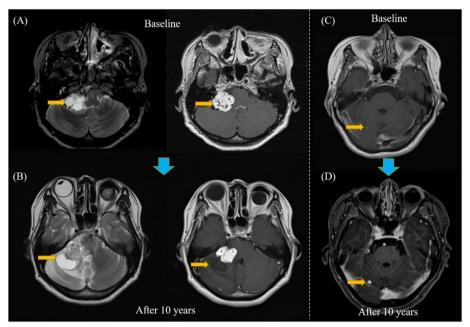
Baseline and 10-year follow-up MRI images of the brains of two male patients in their late 40 s with missense mutations and brain hemangioblastomas with different volumes at baseline. A Axial T2-weighted and enhanced T1-weighted images reveal a relatively large hemangioblastoma (2.5 cm) in the right cerebellum of one patient. B The 10-year-follow-up MRI images show a marked increase in size (4.0 cm), with significant increase in the cystic portion. C Axial enhanced T1-weighted image reveals a tiny hemangioblastoma (0.2 cm) in the right cerebellum of another patient. D The 10-year-follow-up axial enhanced T1-weighted image shows a marginal increase in the size (0.5 cm) of the tumor
